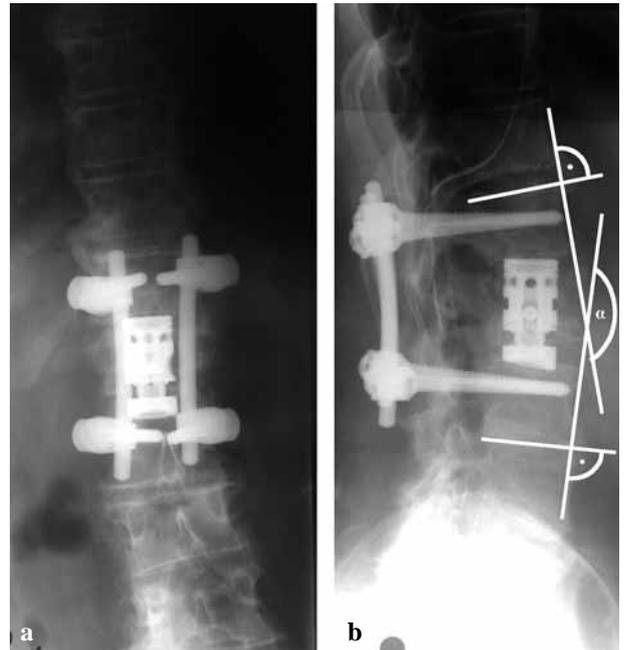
First postoperative x-rays of the same patient : The destroyed first lumbar vertebra is replaced by the Obelisc cage system. The α -angle determines the local kyphosis (angle between the endplates of the two adjacent vertebrae).
